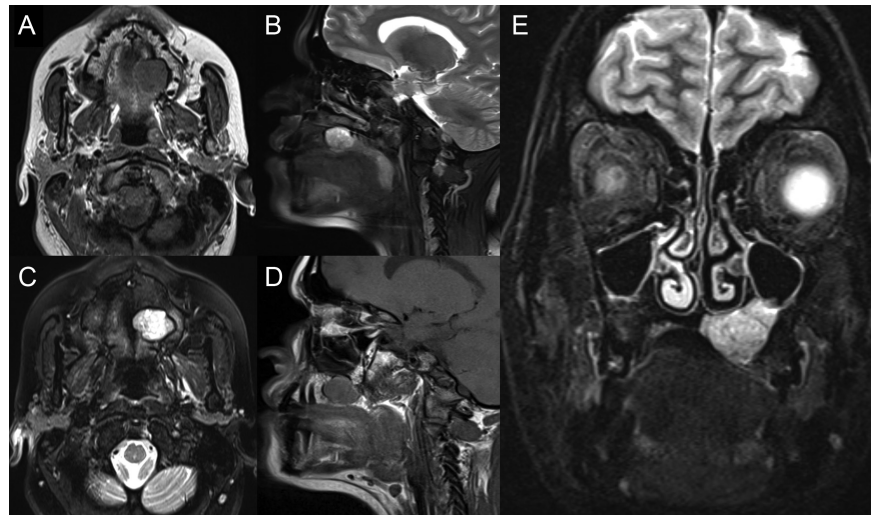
A-D. (A) T1-weighted axial magnetic resonance image (MRI) revealed a well-defined hypointense lesion on the posterior maxilla. (B) Fat-saturated T2-weighted sagittal MRI image revealed a hyperintense lesion on the posterior maxilla. (C) Fat-saturated T2-weighted axial MRI image revealed a hyperintense lesion on the posterior maxilla. (D) T1-weighted sagittal MRI image revealed a well-defined hypointense lesion on the posterior maxilla. (E) Fat-saturated T2-weighted coronal MRI image revealed a hyper-intense lesion on the posterior maxilla.
